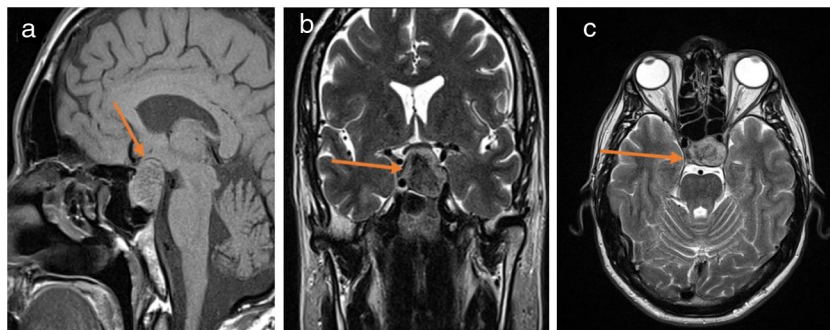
(a–c) Pituitary MRI with and without contrast. (a) Sagittal T1 Sellar mass with obscuration of the pituitary stalk; (b) and (c) coronal and axial T2 – heterogeneous peripherally T2 isointense centrally dark mass with diminished enhancement in the sella turcica extending into the suprasellar cistern with local mass effect. Elevation of the optic chiasm as well as prechiasmatic portion of the left greater than right optic nerve. Findings compatible with pituitary macroadenoma with central hemosiderin deposition suggesting remote hemorrhage.
